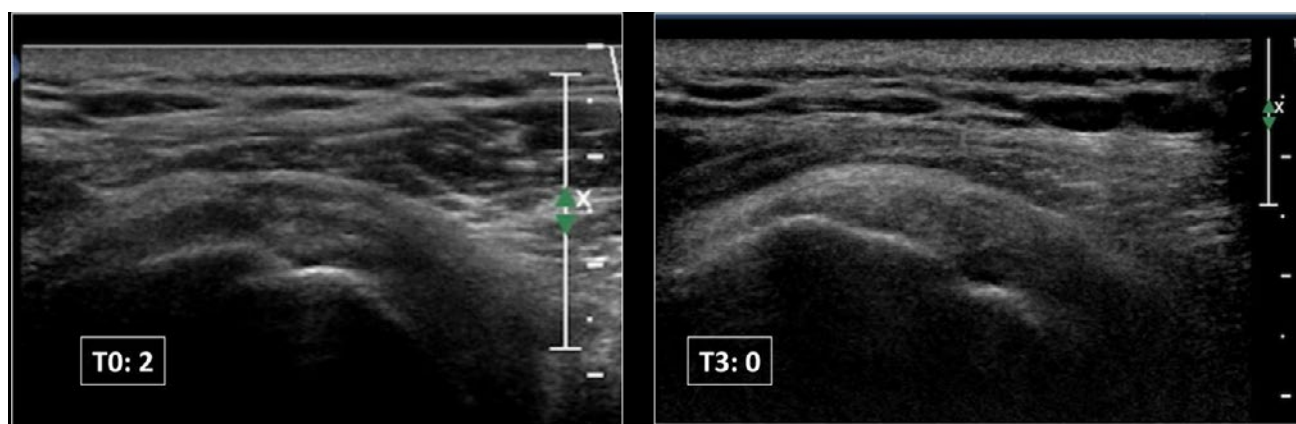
Sonographic assessment of a patient with supraspinatus tendinopathy who switched from a pre-treatment score of 2 to a post-treatment score of 0.
